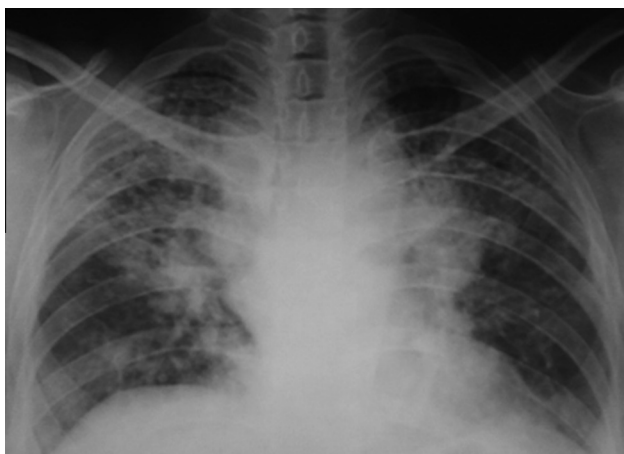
Xray Chest showing bilateral interstitial reticular shadowing.
